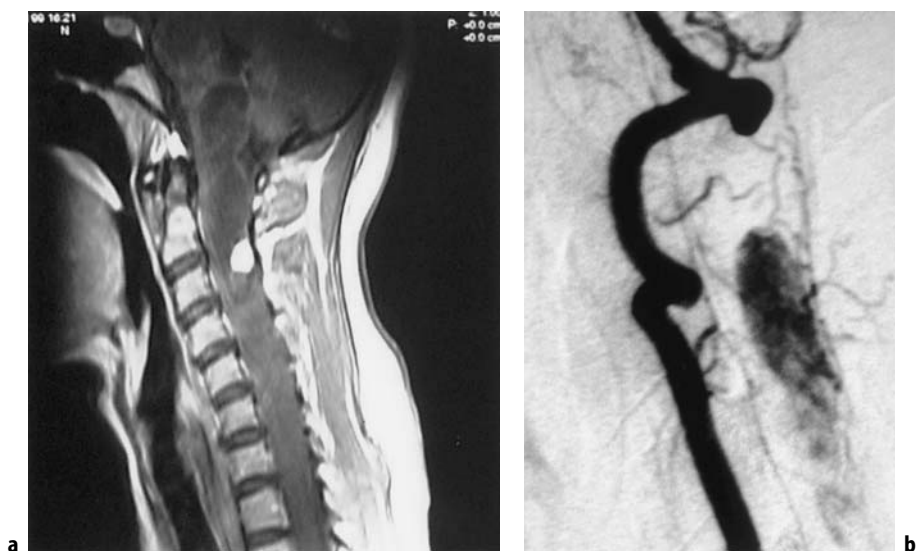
a Intramedullary hemangioblastoma with bright enhancing nodule and cyst on the sagittal T1-weighted image. b The angiogram depicts the vascular anatomy of the lesion.
